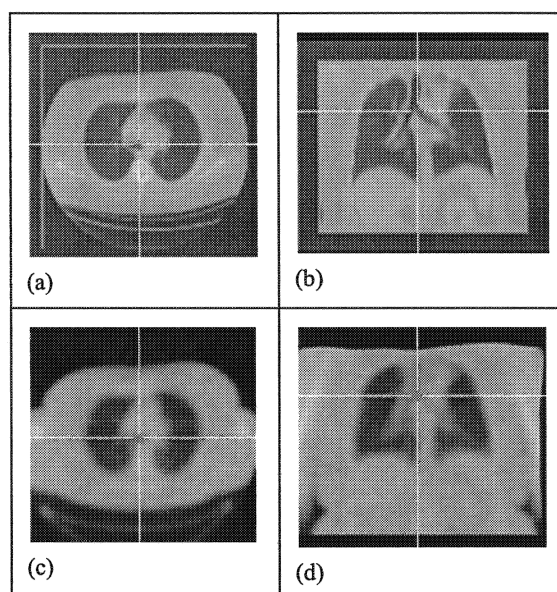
Sample images from a registered TR-CT pair. The top row shows (a) axial and (b) coronal views of the CT while the bottom row shows (c) axial and (d) coronal views of the transformed TR image. The crosshairs show are at the same image coordinates in both CT and TR volumes.
